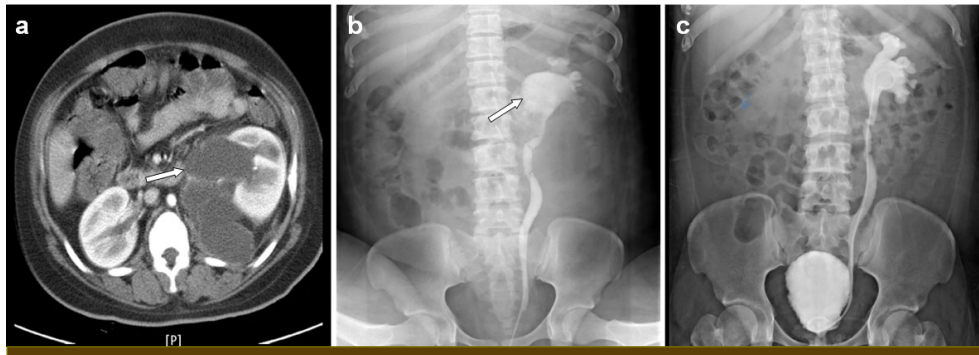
(a) A computed tomography scan of the abdomen showing a huge perirenal urinoma with dimensions of 9.1×12×21 cm (arrow). (b) Retropyelography demonstrating leakage of contrast medium from the ruptured left renal pelvis (arrow). (c) Voiding cystourethrogram showing grade III vesicoureteral reflux of the left kidney.
